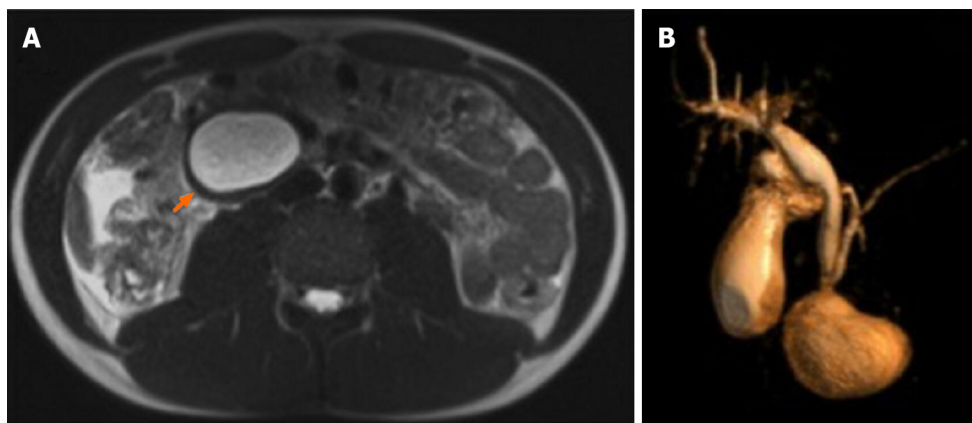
Magnetic resonance imaging on HASTE T2 w sequence. A: Homogeneously hyperintense cyst located within the duodenum, which was partially occluded (arrow); B: On 3D cholangiographic reconstruction, intrahepatic bile ducts were normal, cystic duct was dilated with tortuous course and common hepatic duct presented saccular dilation. Common bile duct had a caliber at the upper limits of the normal range with a regular course and was in communication with periampullary duodenal duplication cysts.
